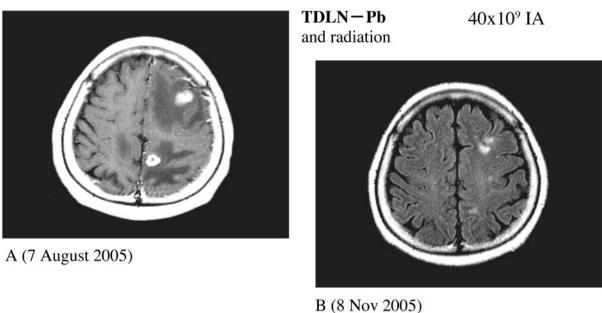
Brain CT findings in a 63-year-old woman (case 2). The patient with pT2N2M0 adenocarcinoma, had surgery after 2 courses of induction chemotherapy. Brain metastasis was found 3 months after surgery (A: August 7 2005). Brain metastasis was controlled after she received irradiation and 4x10<sup>9</sup> TDL-Pb cells (B: Nov. 8 2005).
